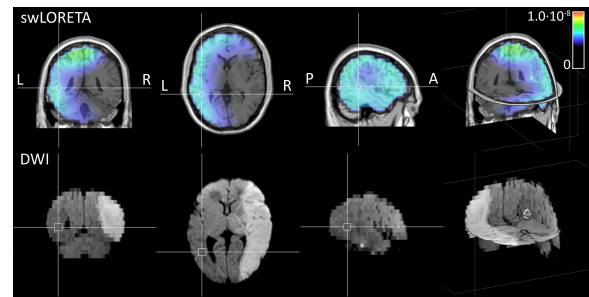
swLORETA reconstruction of EEG recording with a segment length of 25 min. The color bar indicates current density probability, with red and black representing high and low probability, respectively. Note the L-R orientation of the MRI image, analogous to Fig. 2.
